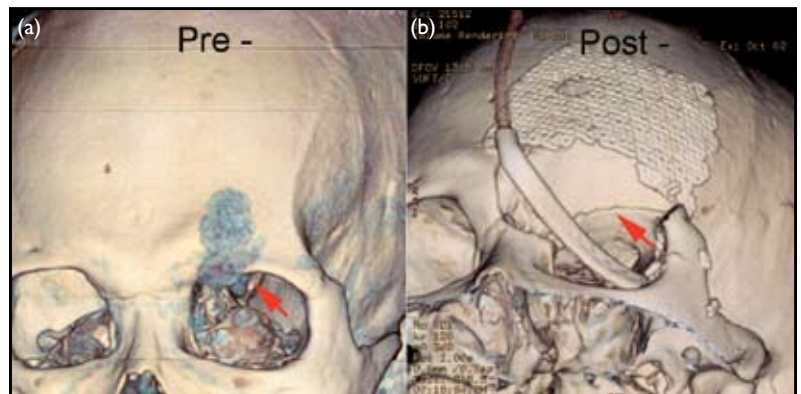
3-Dimensional computed tomographic reconstructions showing (a) the tumour location (red arrow pointing to the skull base extension), and (b) the extent of resection (red arrow pointing to the skull base resection margin)
